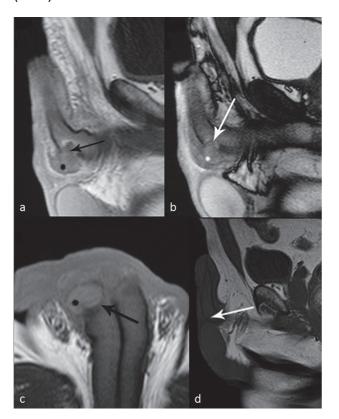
A 37-year-old patient with penile fracture of the left corpus cavernosum. (a) Sagittal T1-weighted image shows a rupture of the tunica albuginea (arrow) and a haematoma extending into the corpus cavernosum (asteriks). Coronal (b) and sagittal (c) T2-weighted images show also disruption of tunica albuginea (arrow) with surrounding haematoma in the distal penile shaft (asteriks). (d) One year later after surgical intervention the tunica albuginea at the rupture site regains its low signal intensity (arrow).
